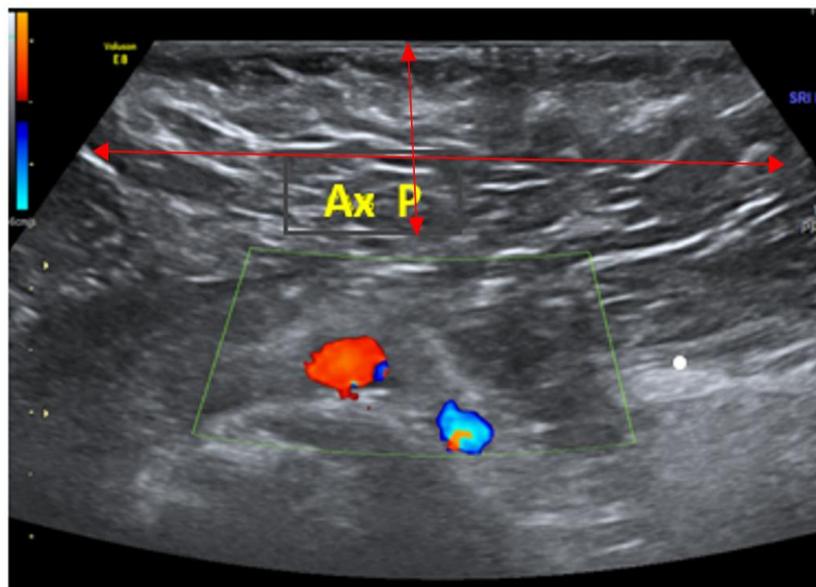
Axillary ultrasound. a. External oblique views, b. magnification view of the axilla shows a supernumerary breast with fibro-glandular pattern
